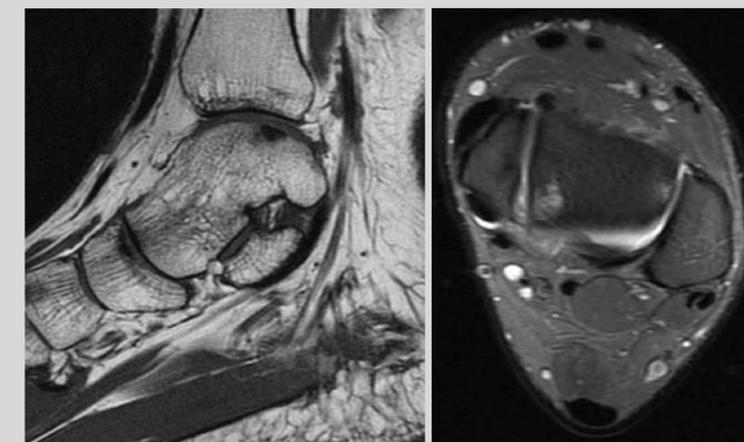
Preoperative MRI demonstrating the talar dome lesions.
